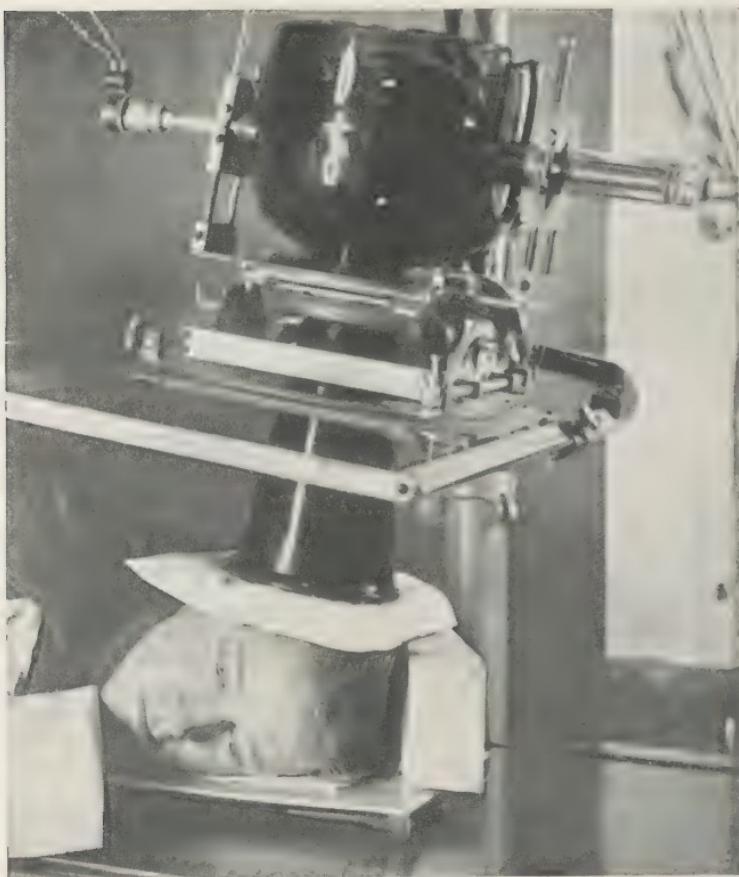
Position for roentgenographing the mastoid region.
